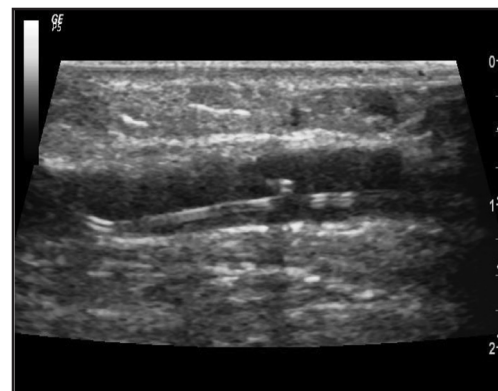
Ultrasound image of guidewire in the radial artery.
